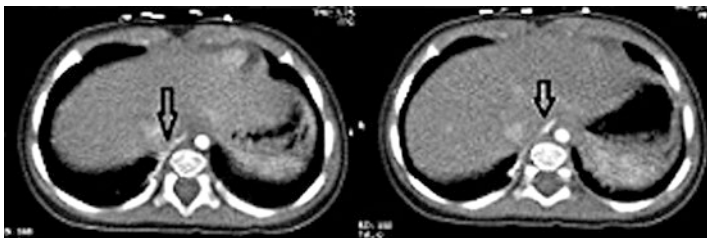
CT scan showing a systemic feeding vessel to a right pulmonary BPS. *Arrow* identifies vessel. This vessel ultimately arose from the celiac plexus.
